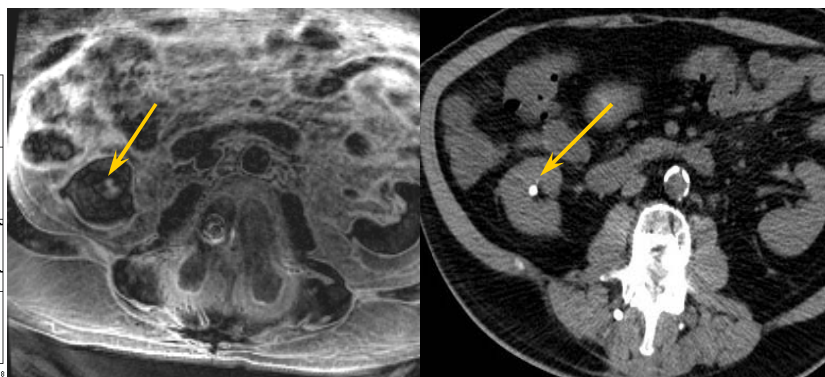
MR difference image shown on the left compared with the CT image on the right. The arrow indicates the renal stone. Note the excellent agreement.
